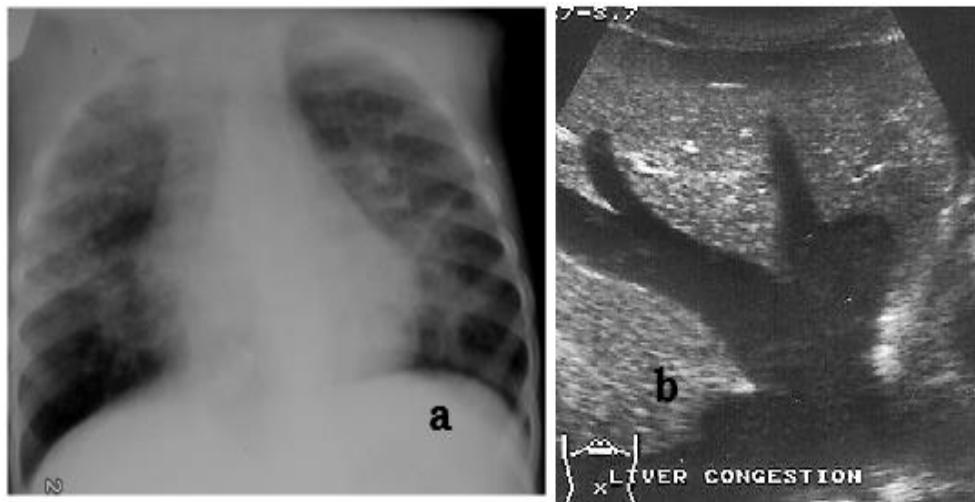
a. Chest radiograph of a child with cardiac failure. Note the bilateral fluffy opacities due to pulmonary oedema. b. Sonogram of the liver showing venous congestion in a patient with cardiac failure.
